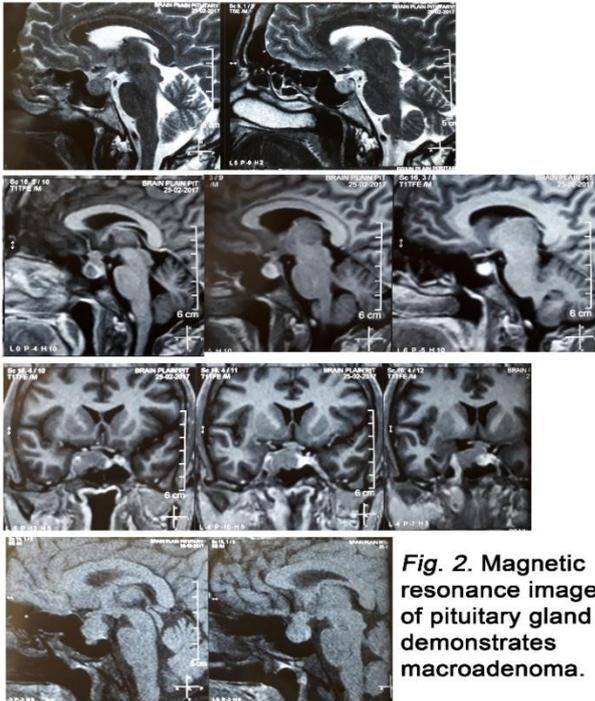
Magnetic resonance image of pituitary gland demonstrates macroadenoma.
